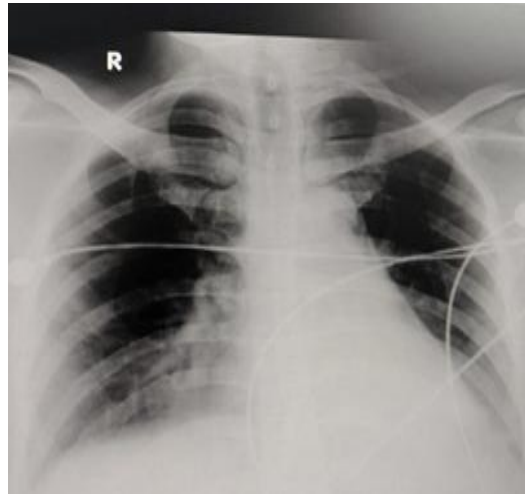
Posteroanterior projection thoracic X-ray examination results
